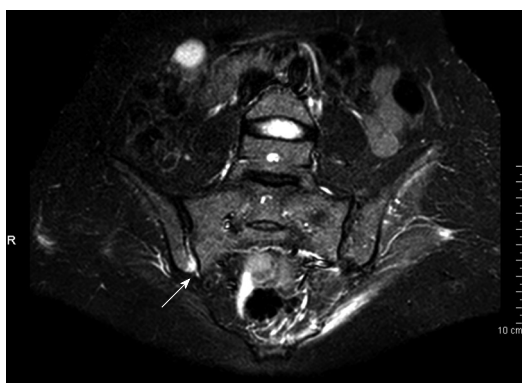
MRI of the sacroiliac joints of a 39-year-old patient with inflammatory back pain and ulcerative colitis (pelvis radiograph was negative for sacroiliitis): STIR MRI of the sacroiliac joints shows bone marrow edema (arrow) of the right sacroiliac joint.
